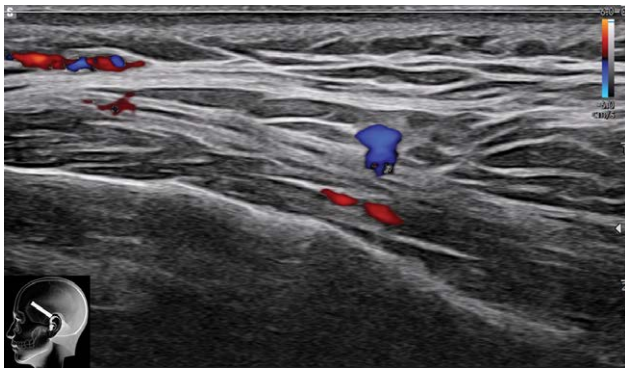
Sonography of the STA, MTA, and DTA before injection in a 54-year-old woman. The STA runs between the upper (layer 4) and main (layer 5) lamina of the superficial temporal fasciae. The MTA was found between the deep layer of the deep temporal fascia and the fat pad. The DTA was detected in the temporalis muscle. The MTV, with the largest diameter, was in the superficial temporal fat pad.
